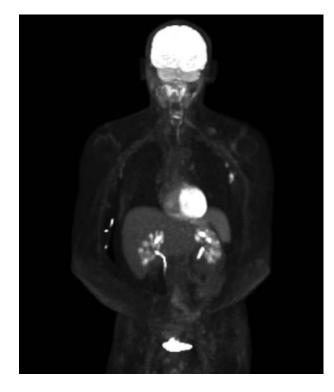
Positron emission tomography–computed tomography demonstrating cervical, left axillary, and right pelvic lymph nodes most consistent with reactive changes and diffusely increased fluorodeoxyglucose uptake in the spleen.
